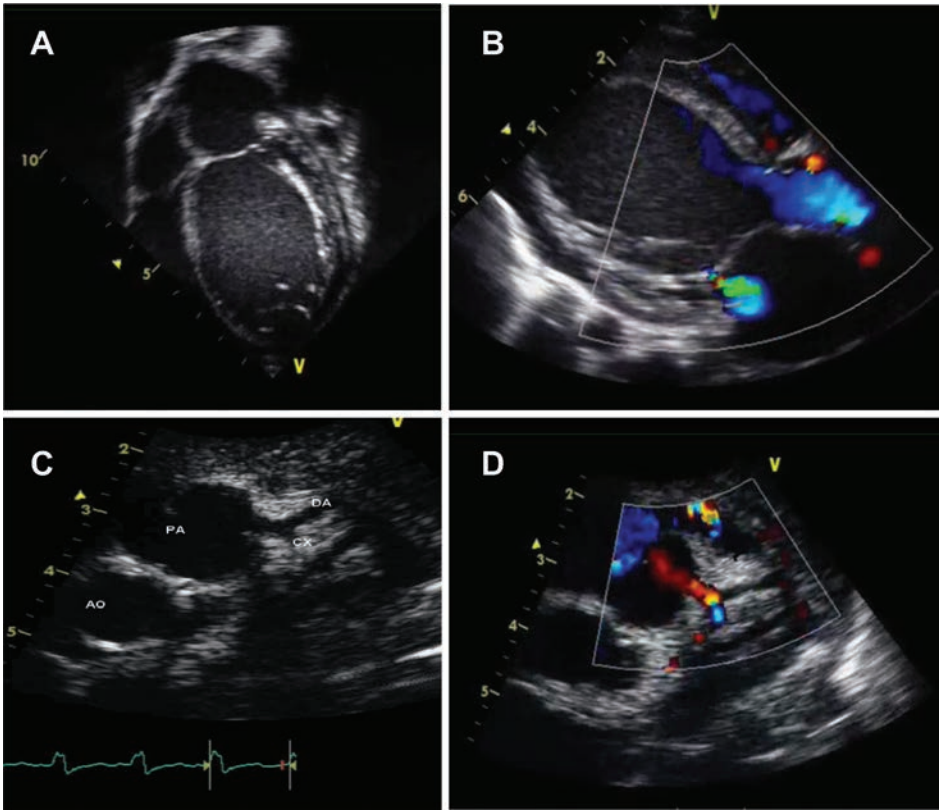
Echocardiograms of patients with ALCAPA. The apical 4-chamber (A) and parasternal long-axis (B) views show a severely dilated and globular LV with secondary MR. Of note, this can be easily misdiagnosed as dilated cardiomyopathy. A 2D parasternal short-axis view (C) demonstrates the takeoff of the anomalous left coronary from the PA. A color Doppler image (D) shows reverse flow from the left coronary artery into the PA. Ao: Aorta, CX: Circumflex coronary, DA: Anterior descending coronary, PA: Pulmonary artery. Images courtesy of Dr. Josh Kailin, www.pedecho.org.
